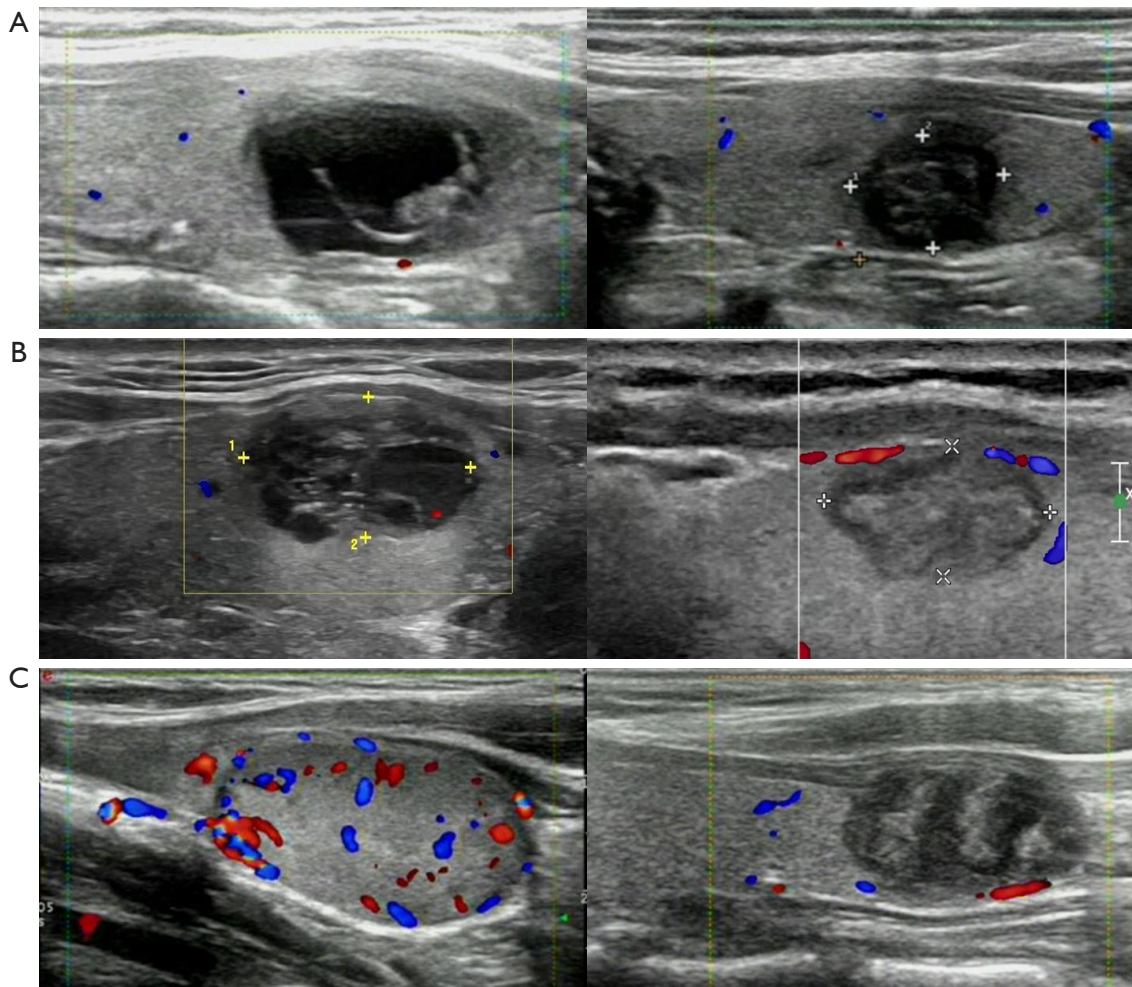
Ultrasound images of the three different components of the nodules before MWA and with VRR >50%. Left and right panels are longitudinal color Doppler flow images of the nodes before and after MWA, respectively. (A) A 55-year-old female with a predominantly cystic nodule in the left lobe measuring 20 mm × 19 mm × 16 mm and approximately 3.2 mL in volume before MWA and approximately 13 mm × 10 mm × 10 mm and 0.7 mL in volume 2 months after MWA, with a VRR of 78%. (B) A 56-year-old male with a predominantly solid nodule in the right lobe measuring 19 mm × 15 mm × 12 mm with a volume of approximately 1.8 mL before MWA and approximately 15 × 10 × 8 mm with a volume of approximately 0.6 mL 2 months after MWA, with a VRR of 67%. (C) A 23-year-old female with a solid nodule in the left lobe measuring 27 mm × 20 mm × 15 mm and approximately 4.2 mL in volume before MWA and approximately 18 mm × 13 mm × 10 mm and 1.2 mL in volume 3 months after MWA, with a VRR of 71%. MWA, microwave ablation; VRR, volume reduction ratio.
